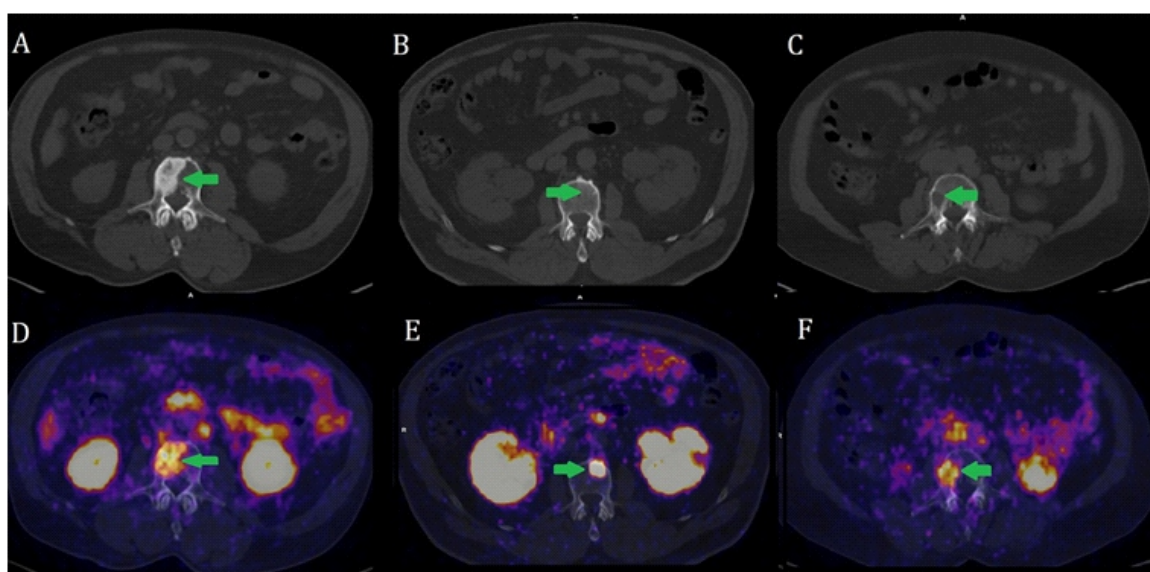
Representative images of different types of bone metastases (green arrow) on ^{68}Ga -PSMA PET/CT. A, D- osteoblastic metastasis; B, E- intramedullary metastasis; C, F- osteolytic metastasis. A, B, C- CT; D, E, F- fusion image. ^{68}Ga -PSMA PET/CT, ^{68}Ga -prostate-specific membrane antigen positron emission tomography/computed tomography.
